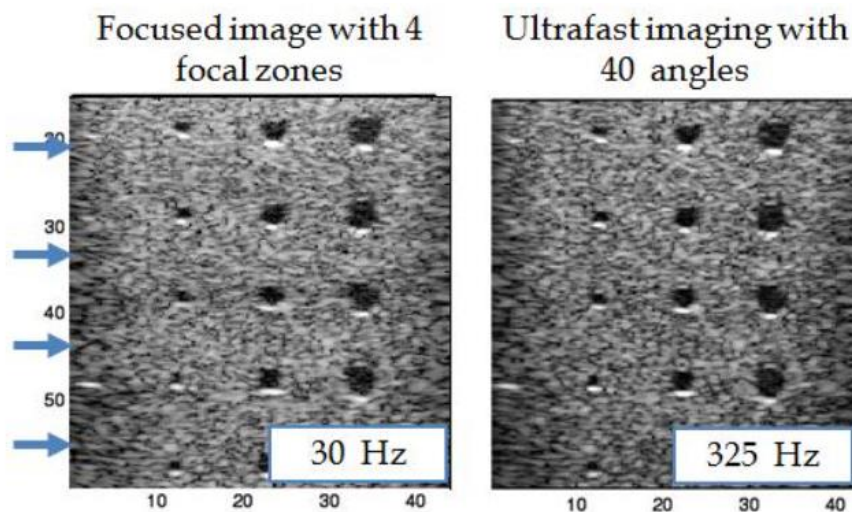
Ultrasound images using the focused approach and the coherent plane wave. The maximum frame rate increases from 30 Hz to 300 Hz
